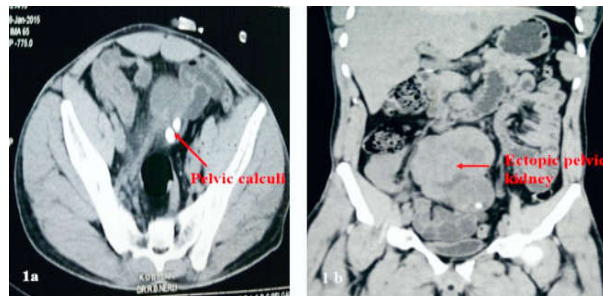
CT image showing ectopic pelvic kidney with pelvic calculi
